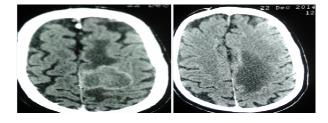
CT Scan up on referral, showing similar findings with the above image but with decreased perilesional edema
